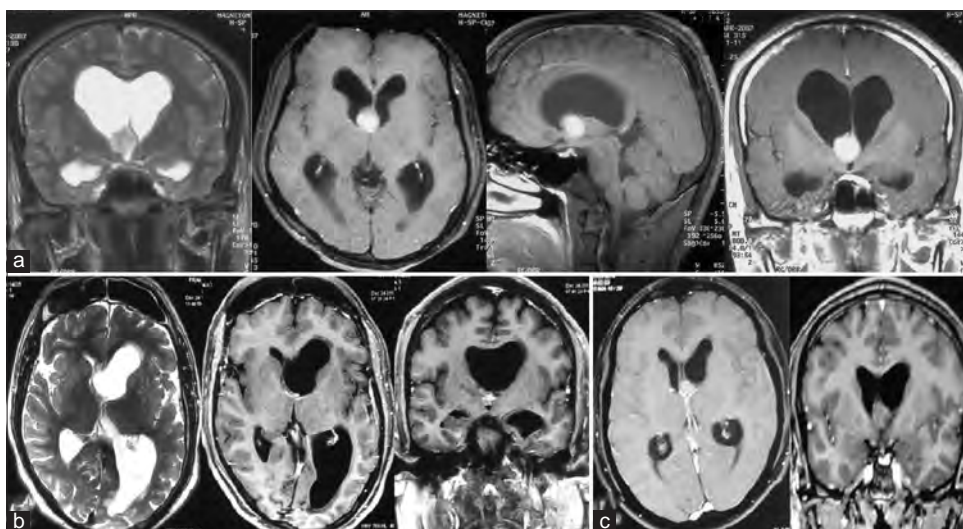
Radiological differential diagnoses. (a) Pilocytic astrocytoma – T2-weighted coronal image and contrast-enhanced T1-weighted axial, sagittal, and coronal images showing a homogeneously enhancing lesion at the foramen of Monro. (b) Neurocysticercosis – T2-weighted axial image and contrast-enhanced T1-weighted axial and coronal images showing a minimally enhancing solid-cystic lesion at the left foramen of Monro, producing asymmetric lateral ventriculomegaly. (c) Lymphoma – contrast-enhanced T1-weighted axial and coronal views showing mildly contrast enhancing lesion, suggestive of a lymphoma
